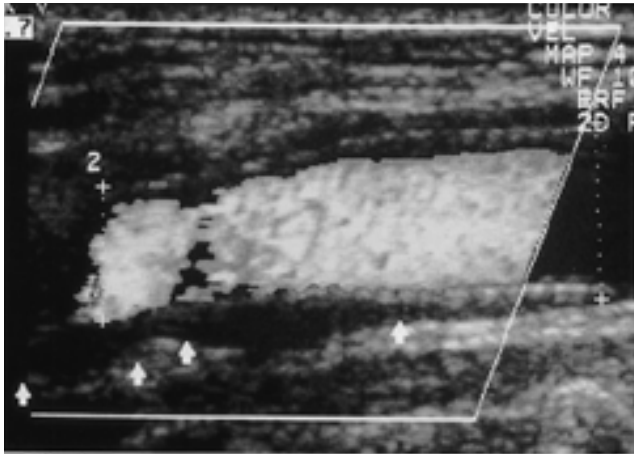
65-year-man with severe stenosis of right ICA underwent stent(8 × 30mm) placement and percutaneous transluminal angioplasty. A hypochoic atheroma(arrows) is noted between stent and arterial wall on color duplex sonogram. US gives good delineation of a atheroma.
